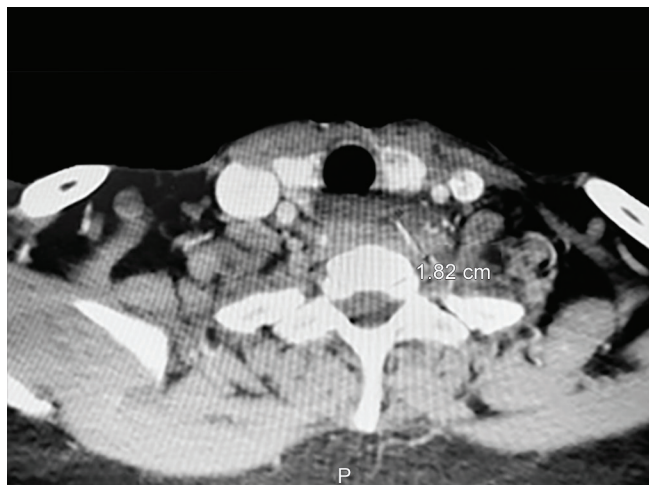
Shows an axial view of CT showing linear opacity of 1.82 cm in length which may represent a fishbone. The hypodense area surrounding the opacity may represent inflammatory and abscess formation
